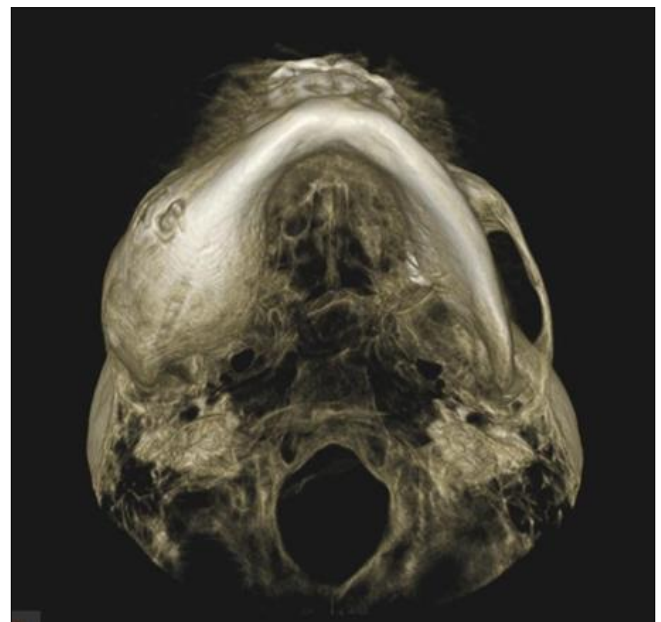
Axial View of CBCT Showing Buccolingually, showed an expansion of 34.3mm.
